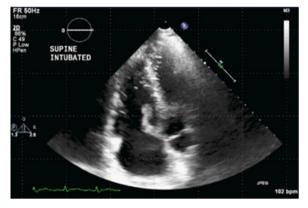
Transthoracic echocardiogram showing a 5 cm vegetation.
